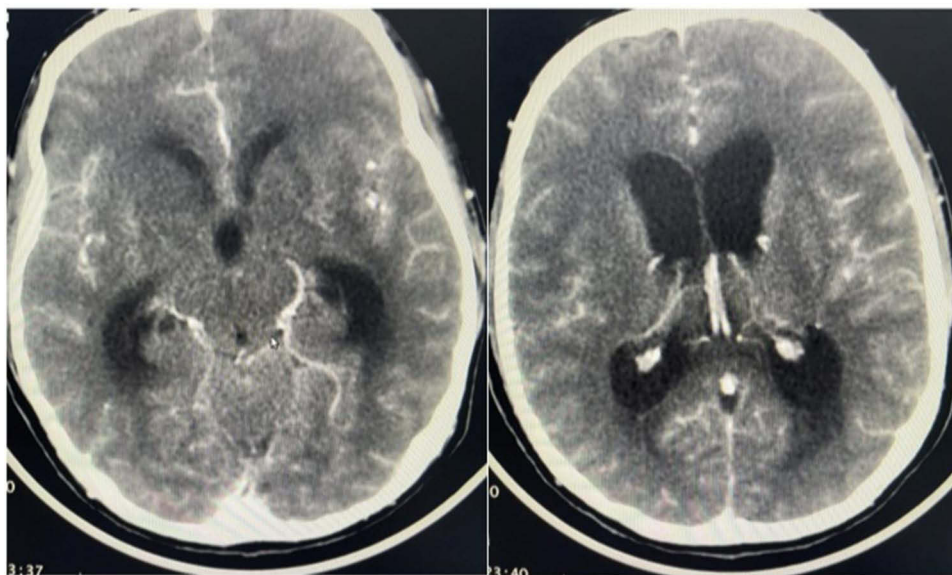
A repeat contrast CT of the brain showed enhancement in basal cistern and hydrocephalus.
